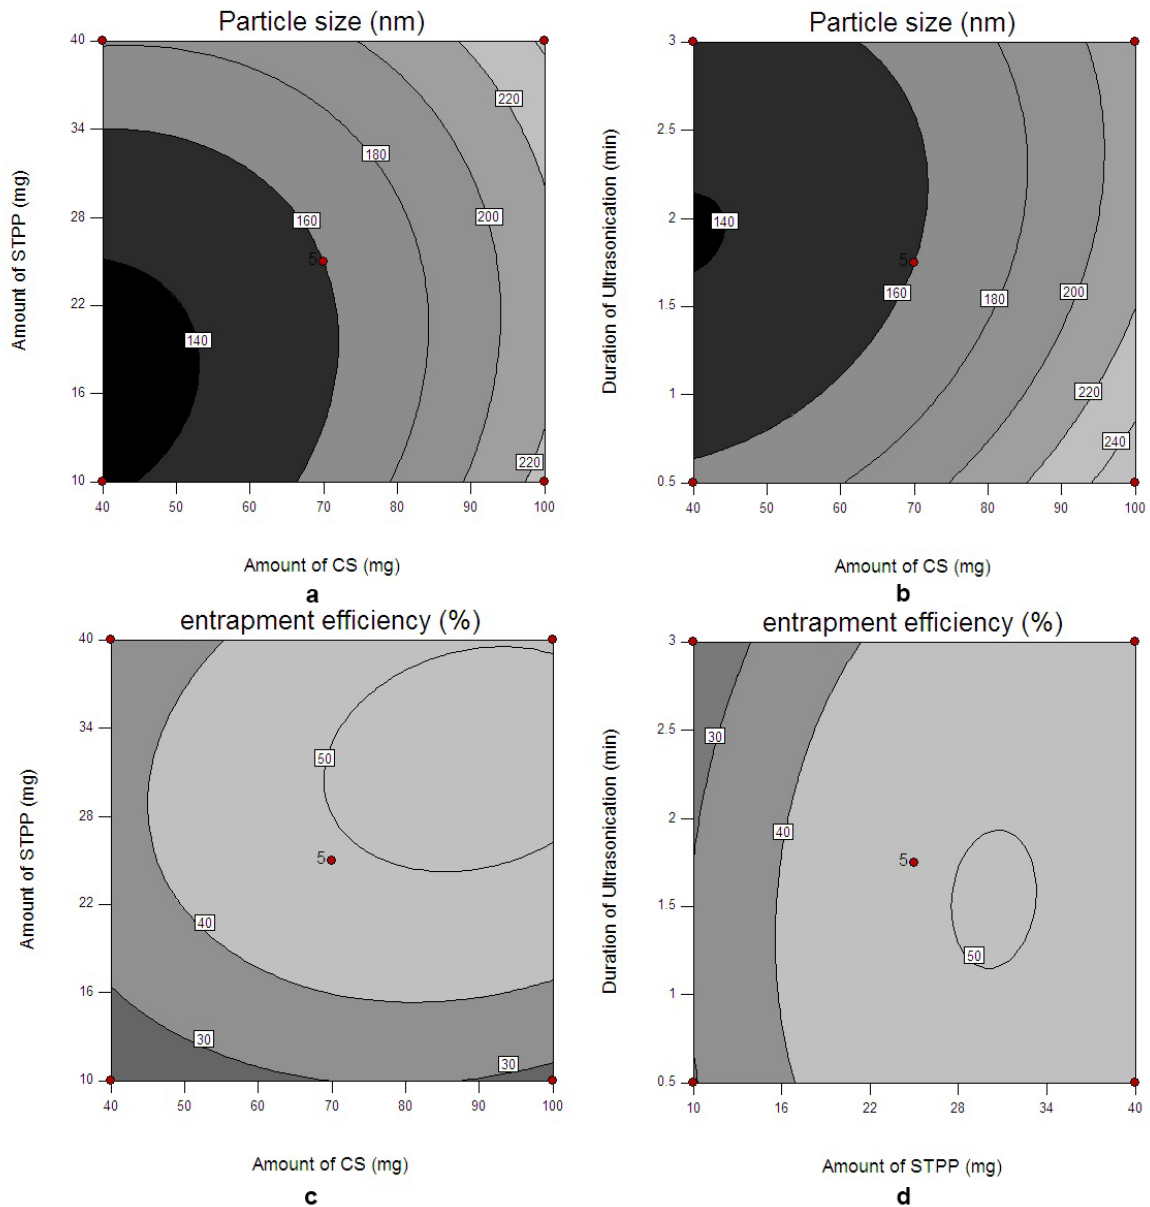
Contour plot of showing the effect of (a) amount of STPP and amount of CS on particle size; (b) amount of CS and duration of ultrasonication on particle size; (c) amount of STPP and amount of CS on entrapment efficiency; (d) amount of STPP and duration of ultrasonication on entrapment efficiency.
